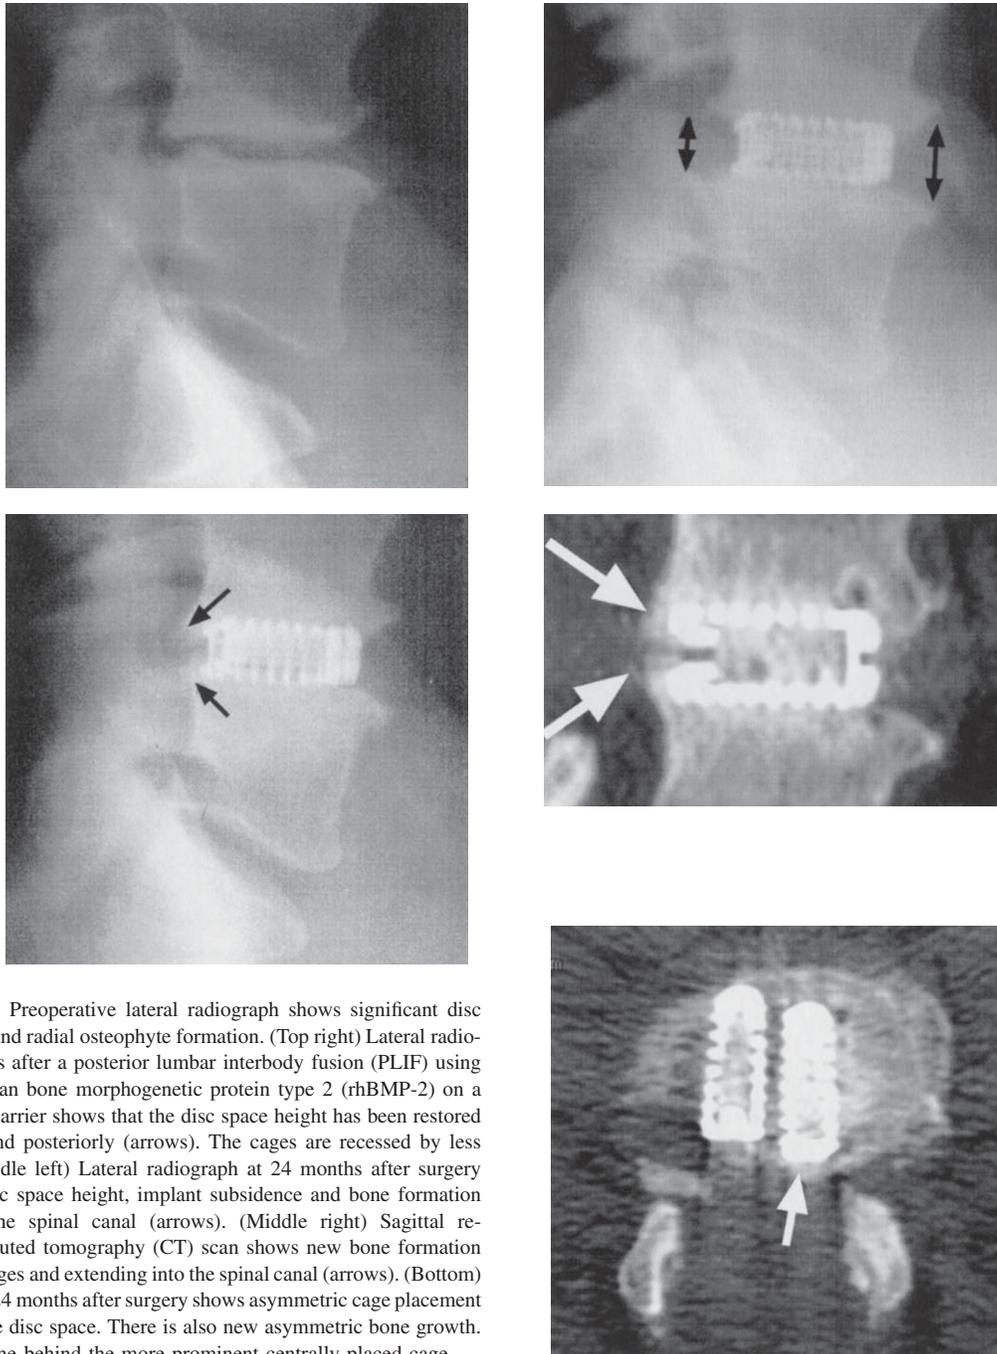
(Top left) Preoperative lateral radiograph shows significant disc space narrowing and radial osteophyte formation. (Top right) Lateral radiograph at 3 months after a posterior lumbar interbody fusion (PLIF) using recombinant human bone morphogenetic protein type 2 (rhBMP-2) on a collagen sponge carrier shows that the disc space height has been restored both anteriorly and posteriorly (arrows). The cages are recessed by less than 3 mm. (Middle left) Lateral radiograph at 24 months after surgery shows loss of disc space height, implant subsidence and bone formation extending into the spinal canal (arrows). (Middle right) Sagittal reconstructed computed tomography (CT) scan shows new bone formation posterior to the cages and extending into the spinal canal (arrows). (Bottom) Axial CT scan at 24 months after surgery shows asymmetric cage placement (arrow) within the disc space. There is also new asymmetric bone growth. There is more bone behind the more prominent centrally placed cage.
